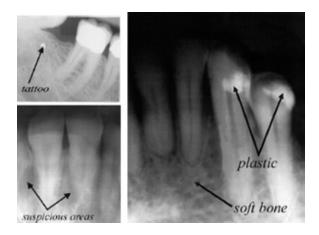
Digital X-rays give superior view
